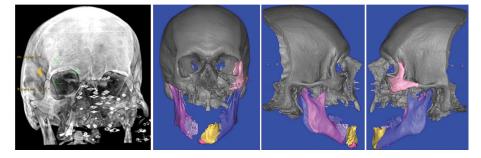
CT and segmented virtual views of patients presented with extensive displaced mandibular and maxillary fractures secondary to gunshot failed suicidal attempt. The majority of gunshot pellets are seen in the region of the left maxillary sinus and ethmoidal air cells as well as the soft tissues overlying the left inferior-lateral aspect of the mandible.
